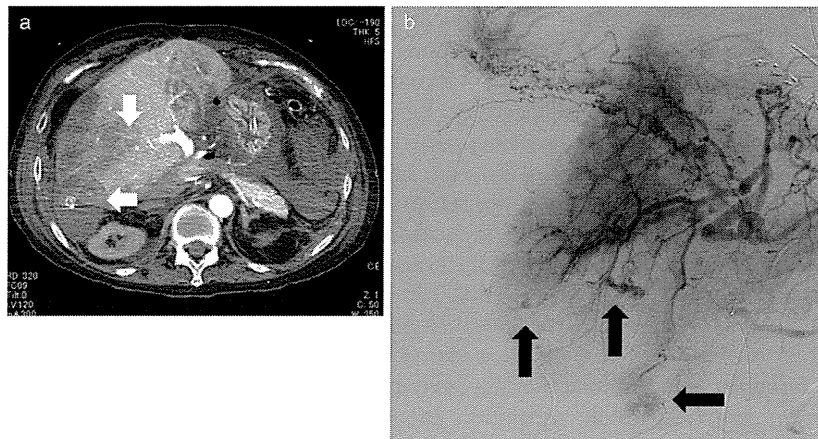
Computed tomography and celiac angiography images of intra-abdominal bleeding on postoperative day 1. (a) Subcapsular bleeding and retention of oozing blood around the retransplanted trisegment graft are seen (arrows). (b) Parenchymal contusion and extravasation from the arteries of segment 5 and 6 are shown (arrows).
